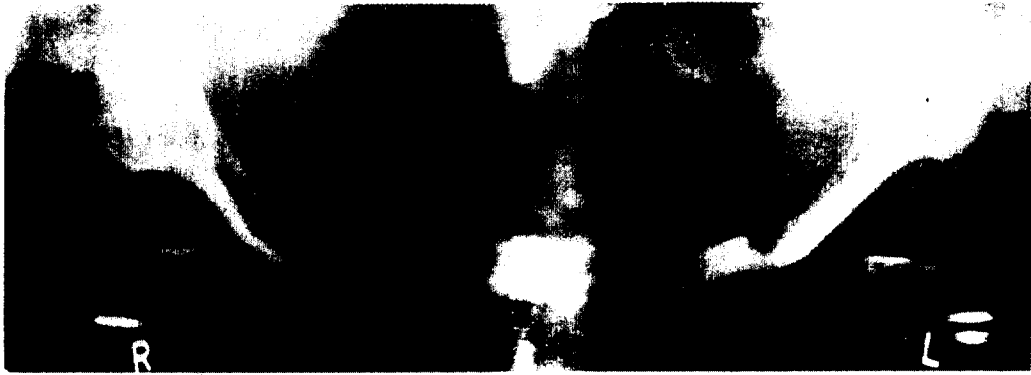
Shortly after the implant was removed the extent of the bone resorption is dearly seen on a panoramic radiograph.
